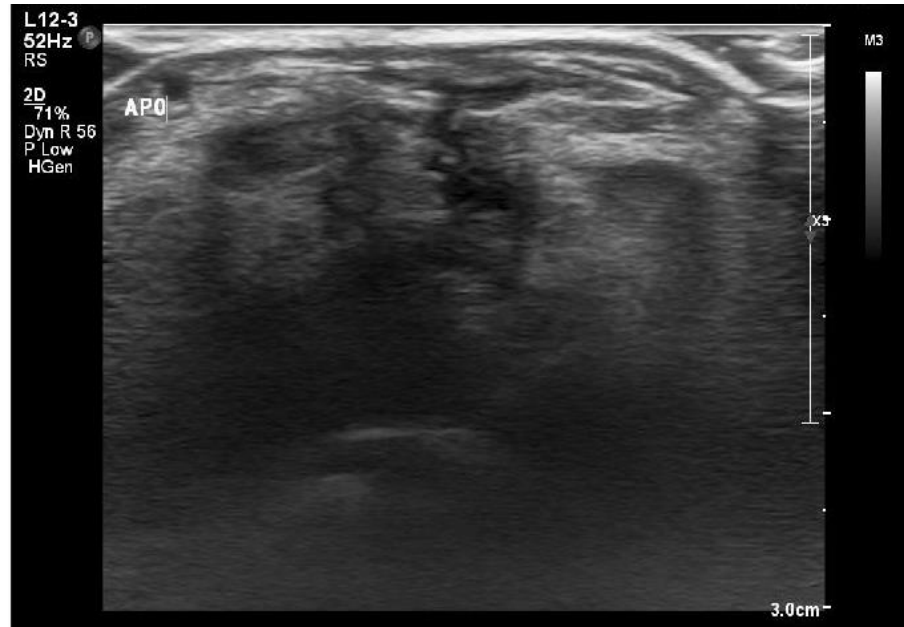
Example of a low-quality Ultrasound scan.
